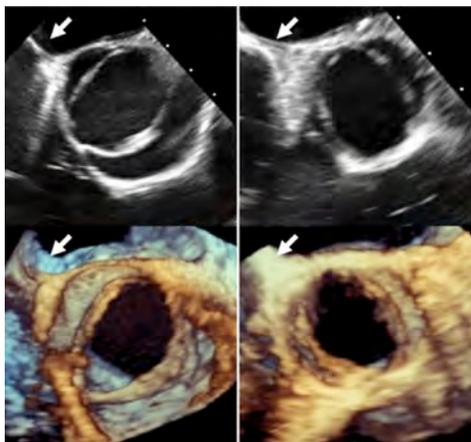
Two different bicuspid aortic valve phenotypes in two-dimensional (on the top) and three-dimensional (bottom) transesophageal echocardiography images. On the right, fusion of the right and left coronary cusps which causes the anterior-posterior orientation of the commissural line is observed (BAV-AP). On the left, the commissural line is in the right to left orientation (BAV-RL). The arrows show interatrial septum.
